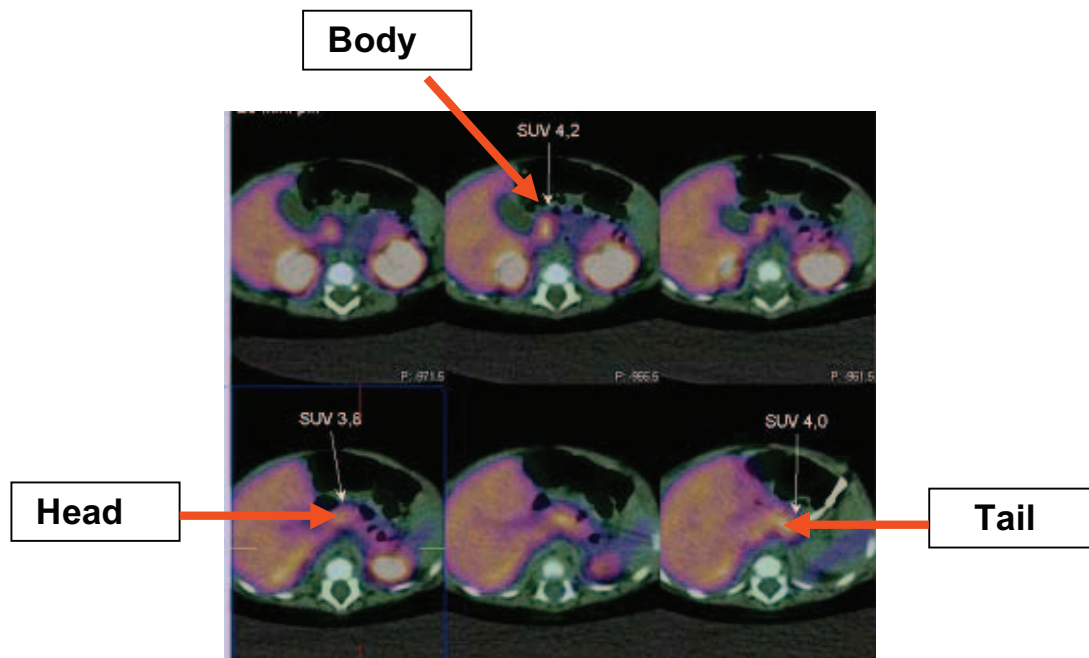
$^{18}\text{F}$ -DOPA-PET/CT scan showing uptake of the  $^{18}\text{F}$ -L-Dopa throughout the whole of the pancreas in patient 1. The principle of this test is that pancreatic islets take up L-3,4-dihydroxyphenylalanine (L-DOPA) and convert it to dopamine by Dopa decarboxylase, present in the islet cells. The standard uptake value (SUV) reflects the intensity of uptake of DOPA. The  $^{18}\text{F}$ -DOPA-PET/CT scan in this patient shows uniformly (in the head, body, and tail of the pancreas) increased uptake of  $^{18}\text{F}$ -L-Dopa, reflecting increased metabolic activity of the islets. The intensity of uptake of the  $^{18}\text{F}$ -L-Dopa by the islets was equivalent to that observed in patients with defects in pancreatic ATP-sensitive  $\text{K}^+$  ( $\text{K}_{\text{ATP}}$ ) channels (7). This fits in with the clinical observation of severe hyperinsulinemic hypoglycemia.
